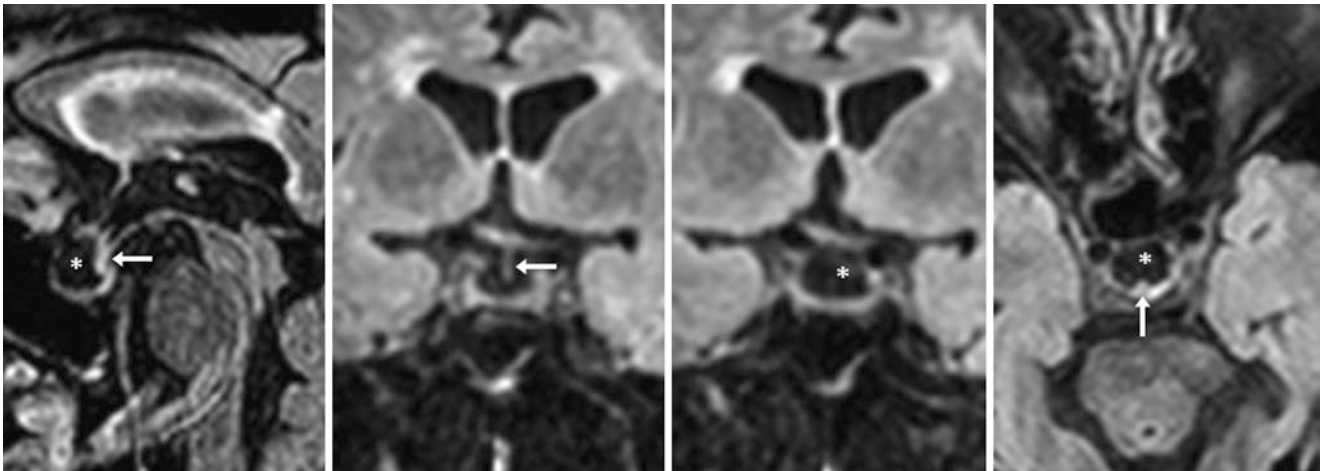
A 66-year-old female patient had a 3 T MRI performed for stroke-like symptoms that was read as negative and an incidental near-complete form of PES (*) on noncontrast FLAIR images reconstructed
